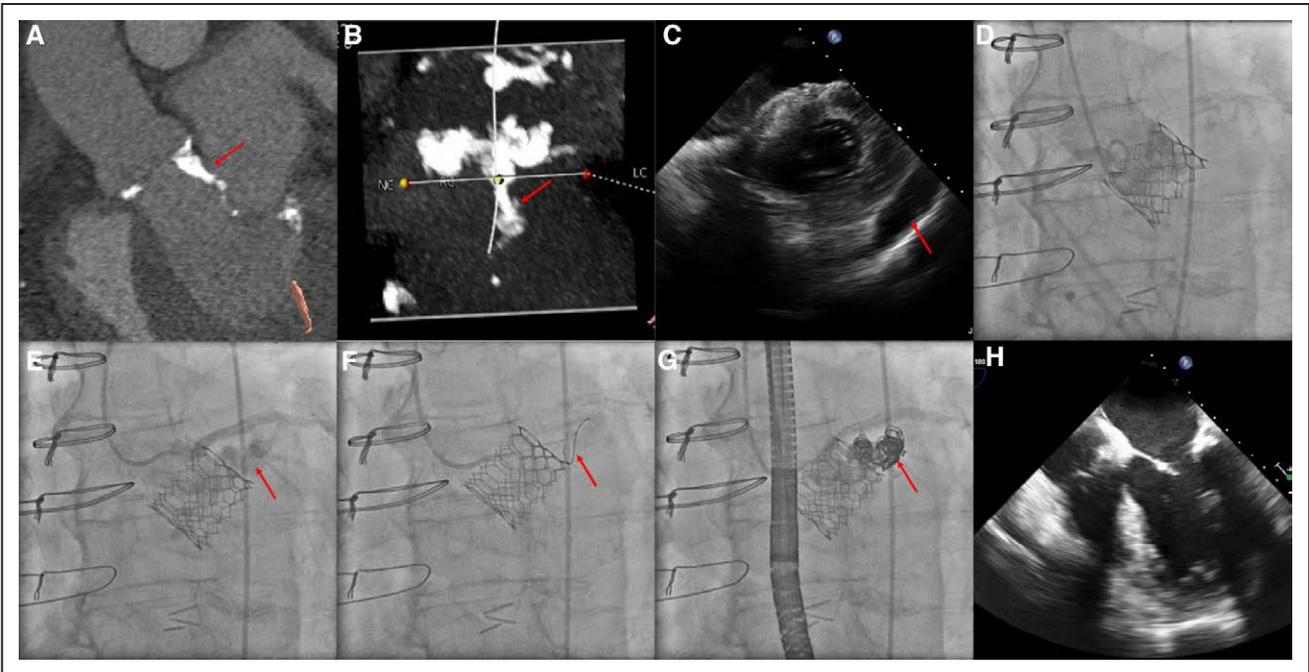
Coiling of the periaortic space created by the root rupture occurring after Sapien 3 valve implantation. A and B, Baseline computed tomogram revealing moderate-to-severe left ventricular outflow tract calcification (red arrow). C, Moderate-to-severe pericardial effusion (arrow) and cardiac tamponade after deployment of a Sapien 3 valve. D, Nonselective aortic root angiogram did not reveal the site of aortic root rupture. E, Selective injection into the coronary cusp with an AL1 catheter revealed the site of aortic root rupture (arrow). F, Balance wire advanced through AL1 diagnostic catheter into the periaortic space (arrow). G, Successful closure of the site of aortic root rupture with 4 Penumbra coils (arrow). H, Final echocardiogram with trivial pericardial effusion.
